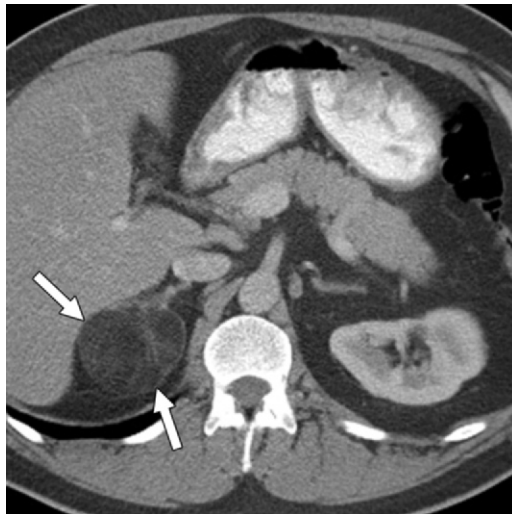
Adrenal myelolipoma in a 45-year-old woman. Axial contrast-enhanced CT image shows a right adrenal mass that contains macroscopic fat (arrows). The mass has higher attenuation than that of retroperitoneal fat because of the myeloid elements.
